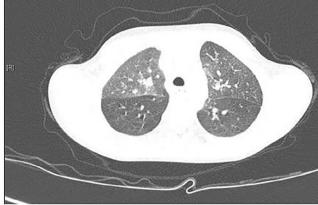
Eighteen month old child with HRCT appearances which mimic neuroendocrine cell hyperplasia of infancy but in fact the underlying biopsy proven diagnosis was desquamative interstitial pneumonia. Whole exome sequencing of the surfactant protein genes revealed no mutations.
